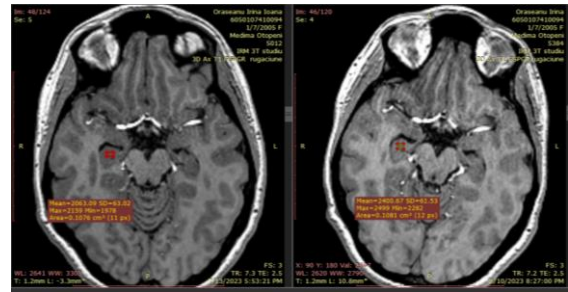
The hippocampus part seen from the MRI results
